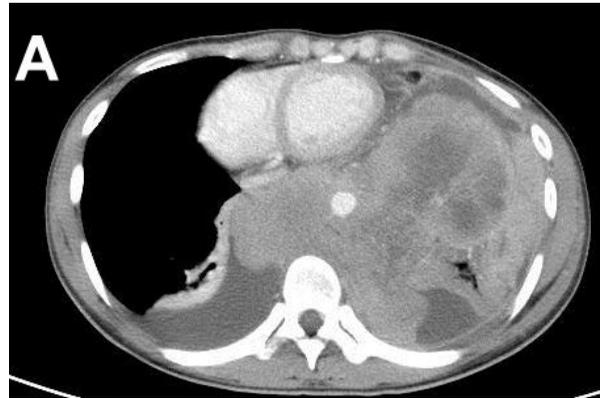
CT revealed a huge heterogeneous posterior inferior mediastinal mass.
